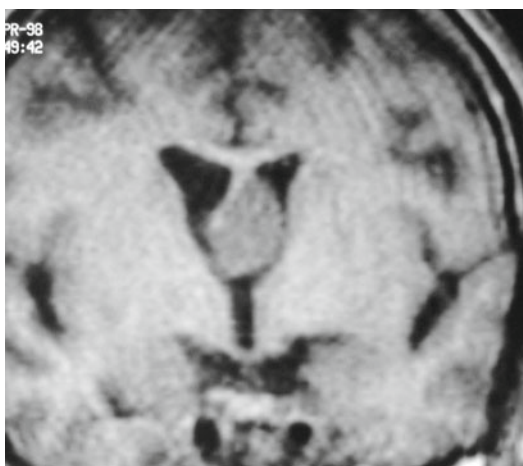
Coronal T1w MR image of a 40-year-old man with persistent headaches. A round mass is seen in the left aspect of the foramen of Monro, causing occlusion of the foramen and unilateral dilatation of the right frontal horn. This is a typical appearance of a colloid cyst
